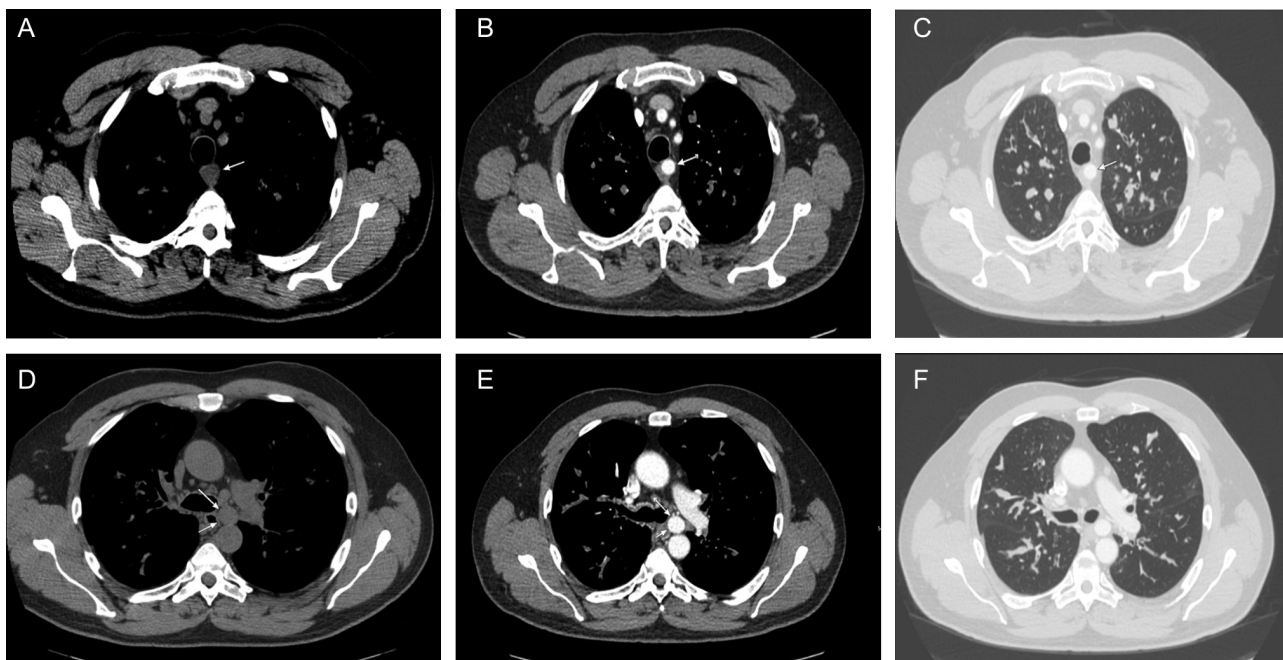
A 55-year-old man with a history of cystic fibrosis (CF). Axial CT images of the chest at mid-tracheal level (A, B, C) and at the level of the Carina (D, E, F). (A and D) Non-contrast enhanced computed tomography (NCECT) mediastinal window images demonstrate two rounded lesions: one behind the trachea and the other anterior to the descending thoracic aorta in the aortopulmonary window (arrows). They are thought to be enlarged lymph nodes. (B and E) Contrast enhanced computed tomography (CECT) mediastinal window images demonstrate enhancement of the previously mentioned lesions (arrows) consistent with vascular structures (bronchial artery aneurysms) without contrast leak. (C and F) CECT lung window images demonstrate background abnormalities of CF with bronchial wall thickening, endobronchial mucus plugging, and bronchiectatic changes.
